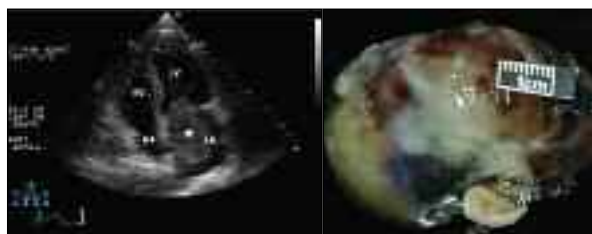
Left atrial myxoma (\*) with attachment to the atrial septum visualized on transthoracic ECHO (left) and pathology (right).
